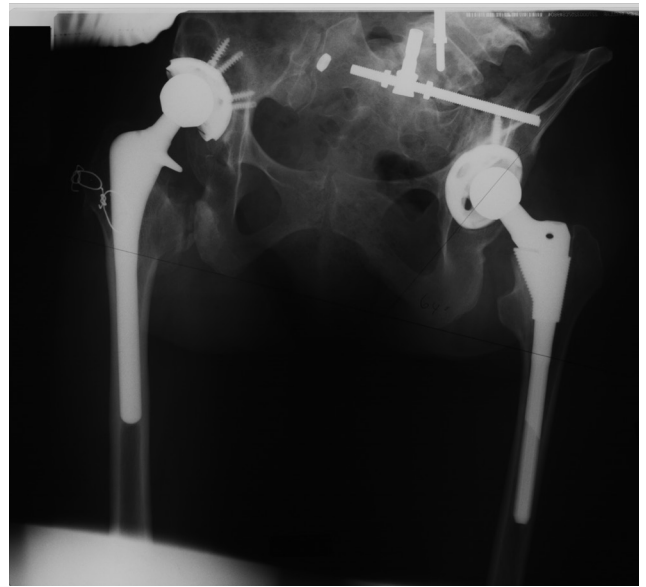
Anteroposterior pelvis radiograph after revision of fractured acetabular liner and downsizing of femoral head.
